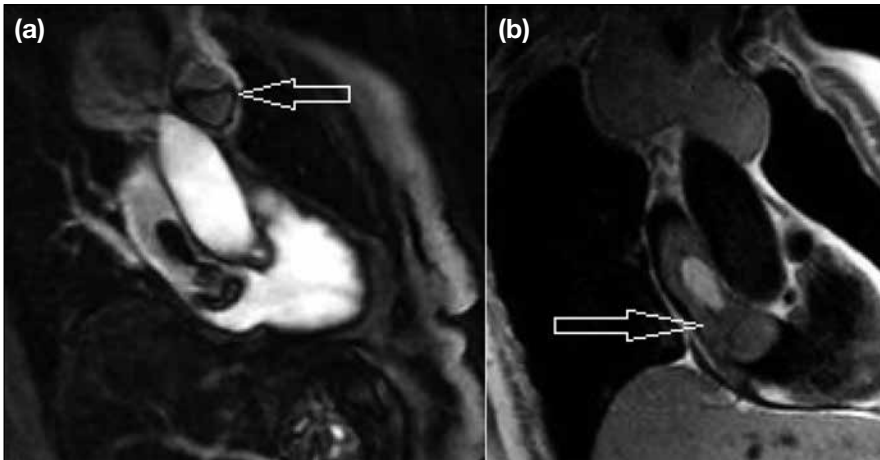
Cardiac magnetic resonance imaging of a 98-year-old female patient with superior vena cava syndrome revealed a retrosternal superior mediastinal mass that was continuous with the thyroid gland. (a) The mass entered the left brachiocephalic vein, expanding its lumen (arrow). (a, b) The tumour cells travelled through the vasculature all the way to the left brachiocephalic vein and superior vena cava, reaching the right atrium (arrow in [b]). The presence of an irregular area at the distal end of the mass that showed no contrast enhancement was consistent with an extension of the tumoural mass accompanying a distally located thrombus. The retrosternal mass was biopsied under ultrasound guidance and the patient was diagnosed with thyroid carcinoma.
